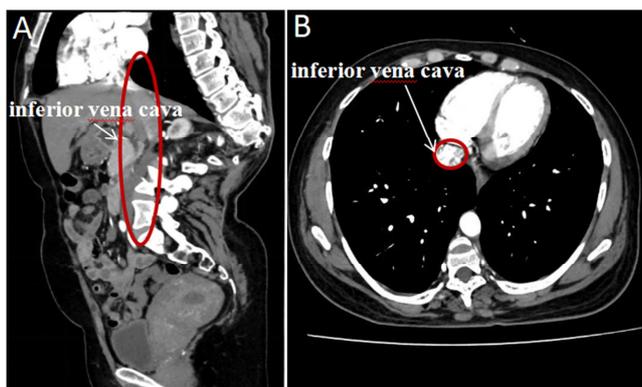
CT shows the inferior vena cava: The inferior vena cava can be seen before operation as being curved due to spinal deformity.
